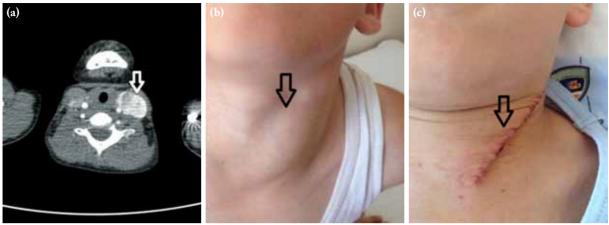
(a) Contrast-enhanced computed tomography image preoperatively, (b) preoperative view of aneurysm, (c) postoperative view of incision.
